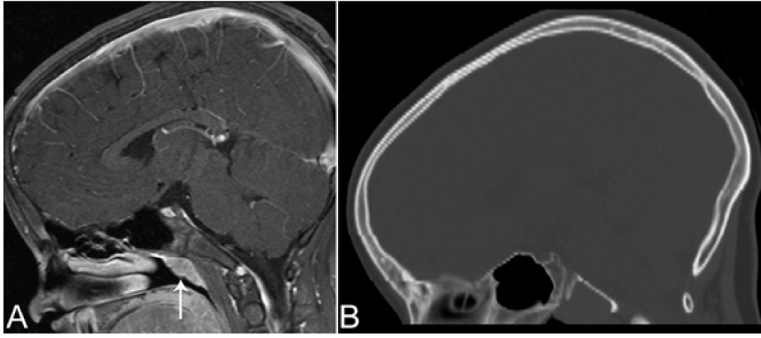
Case 2. (Left) Sagittal T1-weighted MR image with gadolinium enhancement demonstrating chordoma involving the nasopharynx (arrow). (Right) Postoperative sagittal noncontrast CT image showing drilling of the outer cortex and diploe of the clivus.
